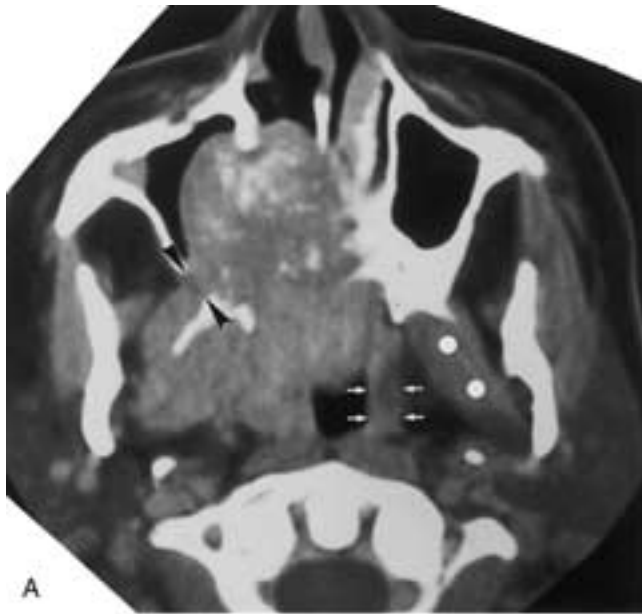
Adenoid cystic carcinoma of the hard palate. A and B, Axial and coronal contrast-enhanced CT scans demonstrate a destructive lesion of the right hard palate. There is erosion of the medial wall of the right maxillary sinus with extension of tumor into the sinus, as well as destruction of the posterior aspect of the nasal septum with involvement of the nasal cavity bilaterally. There is widening of the pterygomaxillary fissure on the right (*arrowheads* in A) and the inferior orbital fissure (*arrowheads* in B), which is highly suggestive of perineural tumor involvement. Involvement of the right masticator space musculature is probable, on the basis of enlargement of the right medial pterygoid muscle, when compared with the normal appearance on the left (*white dots* in A). The normal configuration of the parapharyngeal space fat is lost on the right side compared with the normal left. Extension of the tumor along the pharyngeal constrictor muscle on the right is identified by enlargement and poor definition of this muscle. The normal contour of the left pharyngeal constrictor muscle is indicated by the white arrows in A. C, Coronal T1-weighted MR image demonstrates perineural tumor extension along the right mandibular nerve as it courses through an enlarged right foramen ovale (*white arrows*) into the inferior aspect of the right cavernous sinus.
